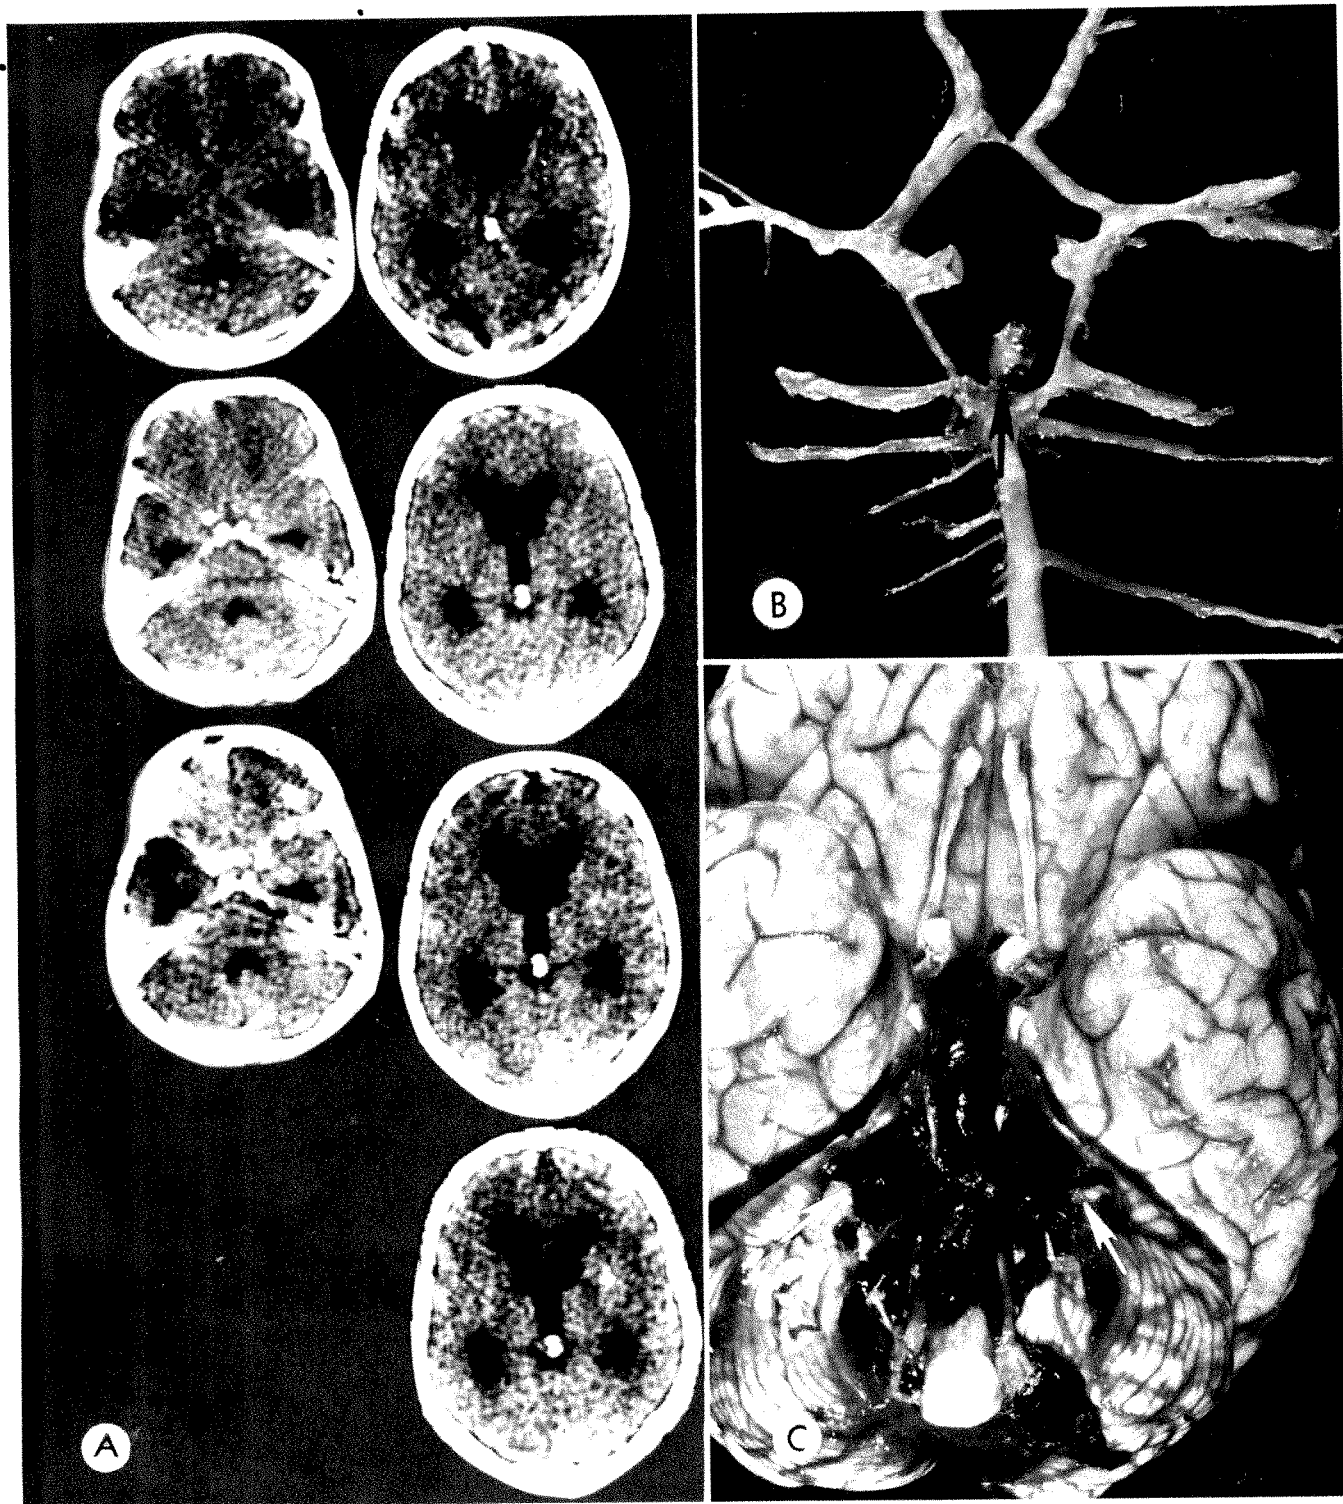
Case 4: evaluation of ventricular size. *A*, Upper to lower, CT scans on days 1, 6, 14, and 22. Only transient decrease in hydrocephalus: sylvian fissures not visualized. *B* and *C*, Aneurysm (arrow) and clot in cisterns (arrows) found at autopsy on day 25.
